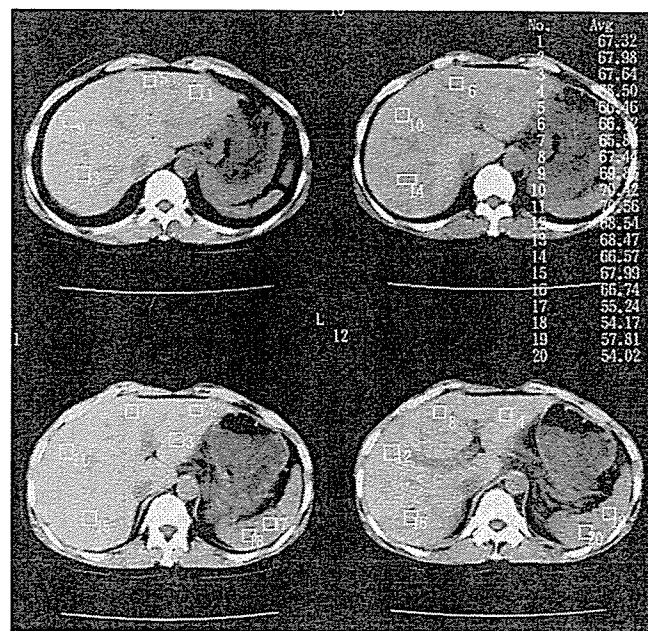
Calculation of liver-to-spleen CT attenuation values ratio. Hepatic and splenic attenuation values were measured on noncontrast-CT scans by using 16 circular region-of-interest (ROI) cursors in the liver and four in the spleen. In the liver, each four ROIs were measured at right anterior, right posterior, left medial, and left lateral segments. The size of one picture is 8×9 cm. Four sequential slices used for calculation of L/S ratio are demonstrated.
